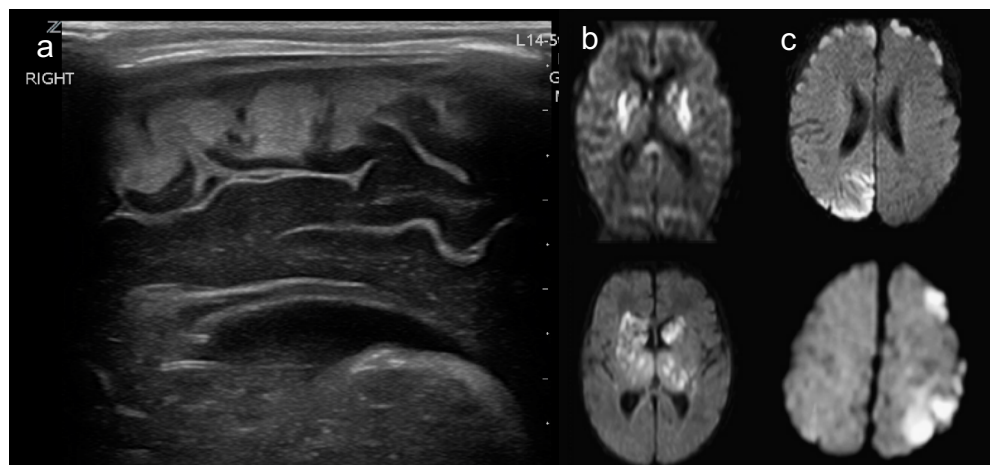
A cranial ultrasound (a) performed using a linear probe in the sagittal plane showing a) focal increased cortical echogenicity suggestive of cortical infarction (credit C Hagmann). Diffusion weighted MRI showing b) a deep arterial ischaemic stroke in GBS meningitis and c) multiple cortical infarctions in GBS meningitis (Algubaisi et al., 2015, Hernandez et al., 2011).
